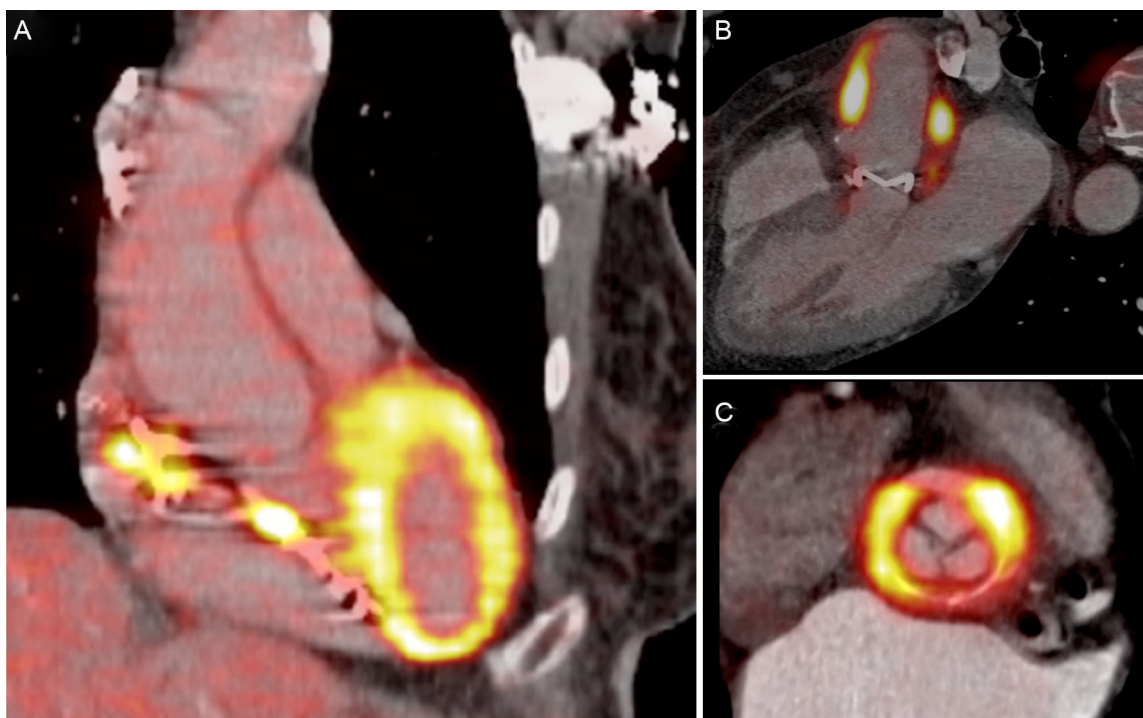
Fusion positron emission tomography/computed tomography images with ^{18}F -fluorodeoxyglucose of patients with endocarditis. A, pacemaker lead; B, Bentall procedure. C, mechanical aortic prosthesis.
